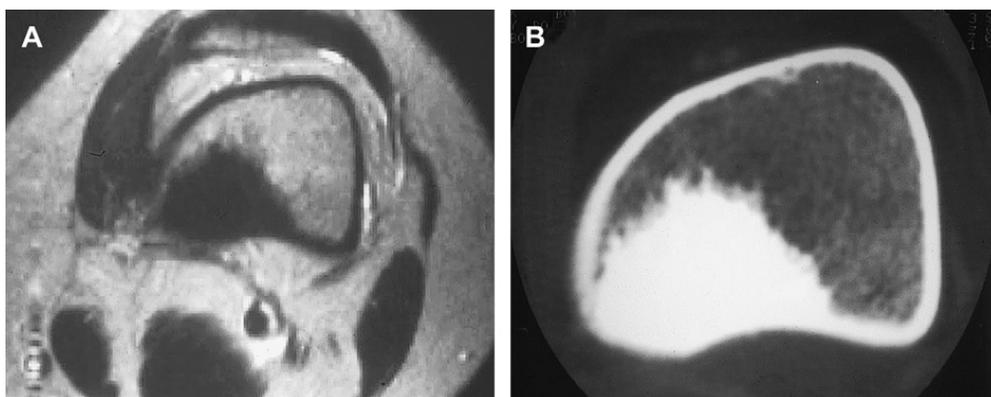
Giant bone island (enostosis) in the distal femur. (A) Axial T2-weighted spin-echo MR image of the distal femur shows a large mass with decreased signal intensity, similar to that of cortical bone, and spiculated margins with the adjacent marrow. T1-weighted image (not shown) had a similar appearance. (B) Corresponding noncontrast CT scan shows the spiculated margin to better advantage.
